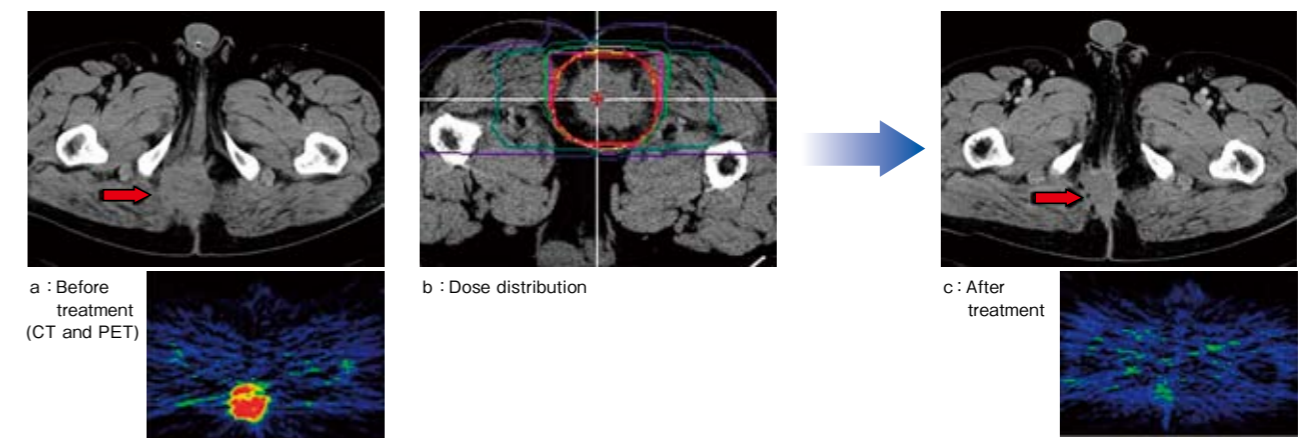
5 Rectal cancer (postoperative local recurrence). After irradiation with 73.6GyE/16 fractions, the tumor decreased in size markedly and PET showed that the abnormal accumulation of FDG had disappeared.
